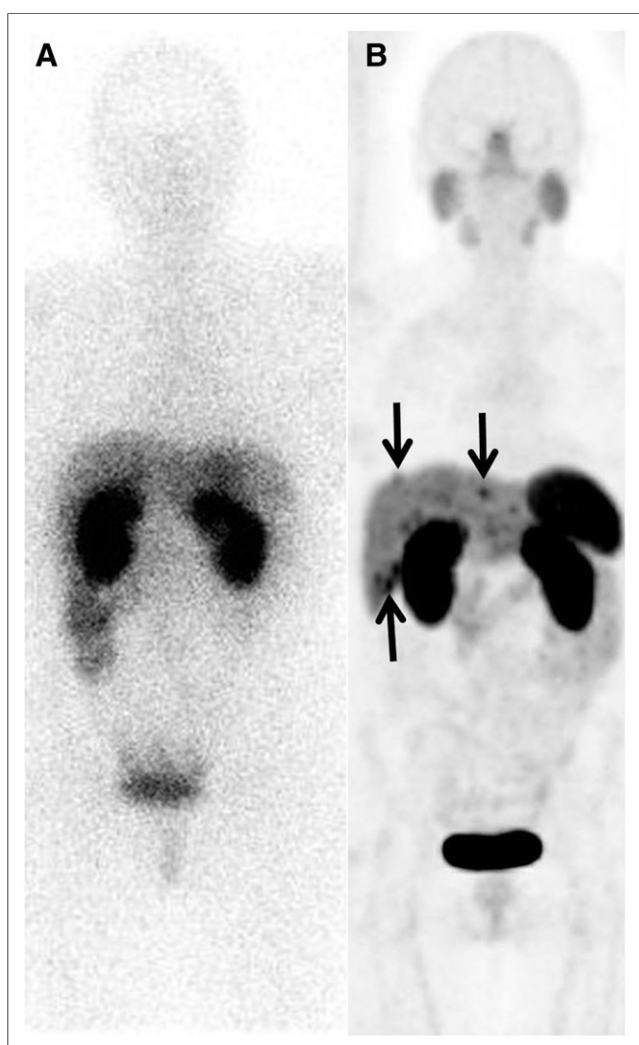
¹¹¹In-DTPA-octreotide SPECT/CT (A) and ⁶⁸Ga-DOTATATE PET/CT (B) (maximum-intensity projections shown) of patient with suspected recurrence of small bowel NET in liver. One metastasis was suspected on SPECT/CT (not shown). Nine liver metastases were found with PET/CT, resulting in change in surgical plan. Findings confirmed at surgery.
